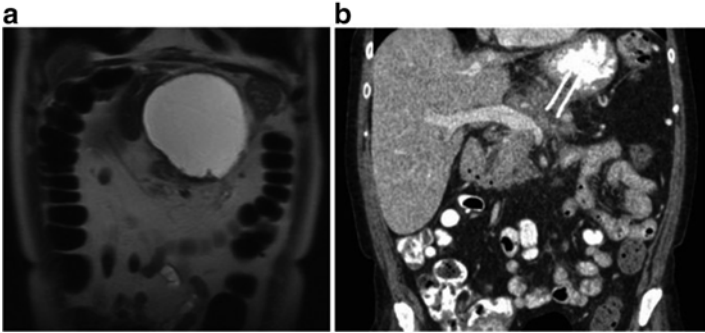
(a) MRI showing a large pseudocyst in a patient with alcoholic pancreatitis. EUS guided cystogastrostomy was performed and two metallic stents were placed. (b) CT showing almost complete resolution of the pseudocyst
